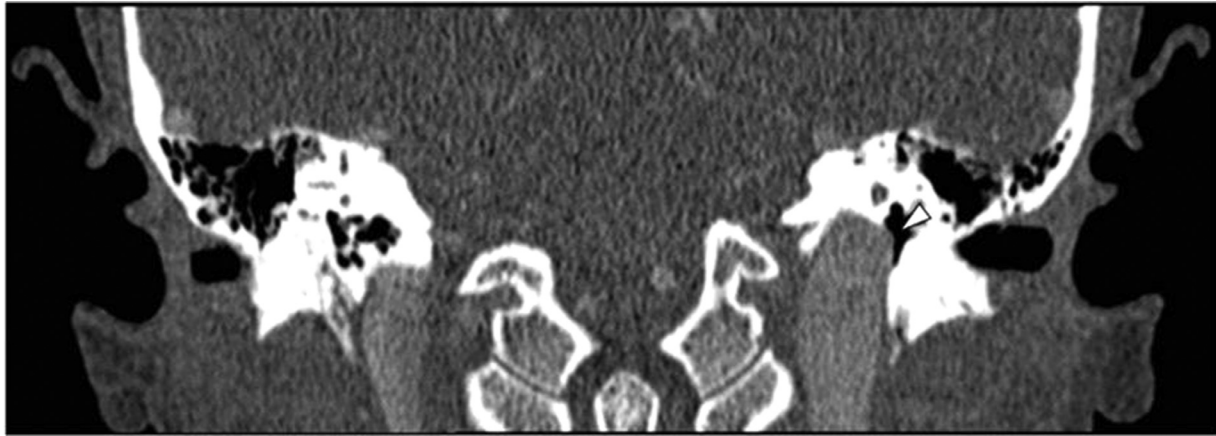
Coronal view of both middle ears by computed tomography in a patient with pulsatile tinnitus in the left ear. The asymmetry of both jugular bulbs can be observed at the level of the jugular foramen, with dominance and elevation of the left jugular bulb. Note the sigmoid plate dehiscence on the left side (white arrowhead), which conditions discrete protrusion of the left jugular bulb into the middle ear.
